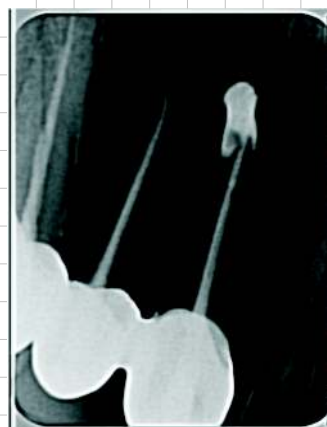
Preoperative radiograph showing radiopaque foreign material near the apex of permanent maxillary right central incisor and overfilled gutta percha in right lateral incisor
